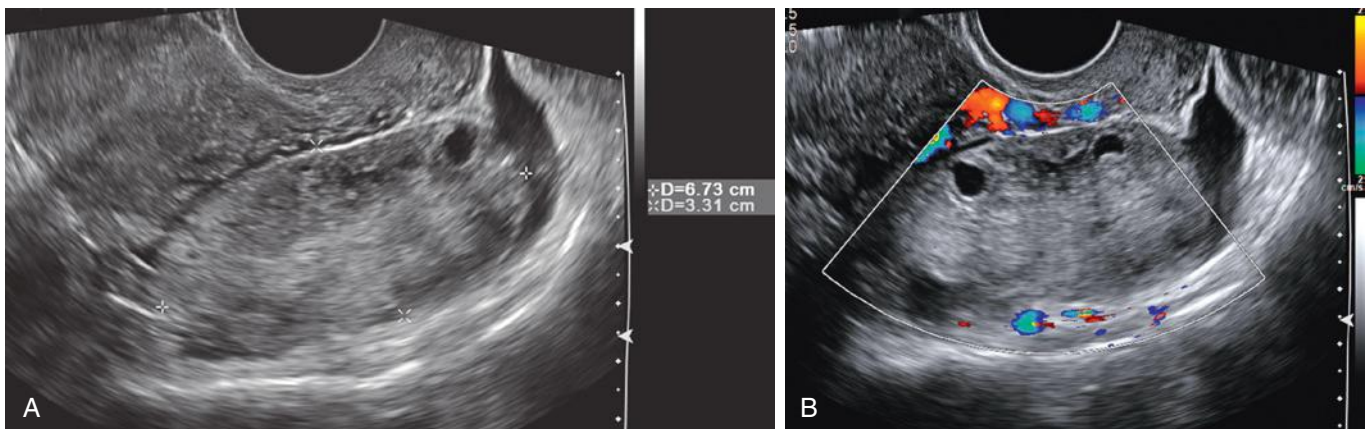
Ovarian torsion with infarcted necrotic ovary. A, Transvaginal scan demonstrates an enlarged ovary (calipers) with heterogeneous echotexture and a small amount of adjacent free fluid. B, Color Doppler image, optimized with “low flow” settings, demonstrates no flow to the ovary. Note thin echogenic walls of the anterior peripherally displaced follicles, the follicular ring sign. At surgery, the ovary and tube were twisted three times and appeared necrotic. Pathologic examination confirmed hemorrhage, congestion, and infarction of the ovary and fallopian tube.
